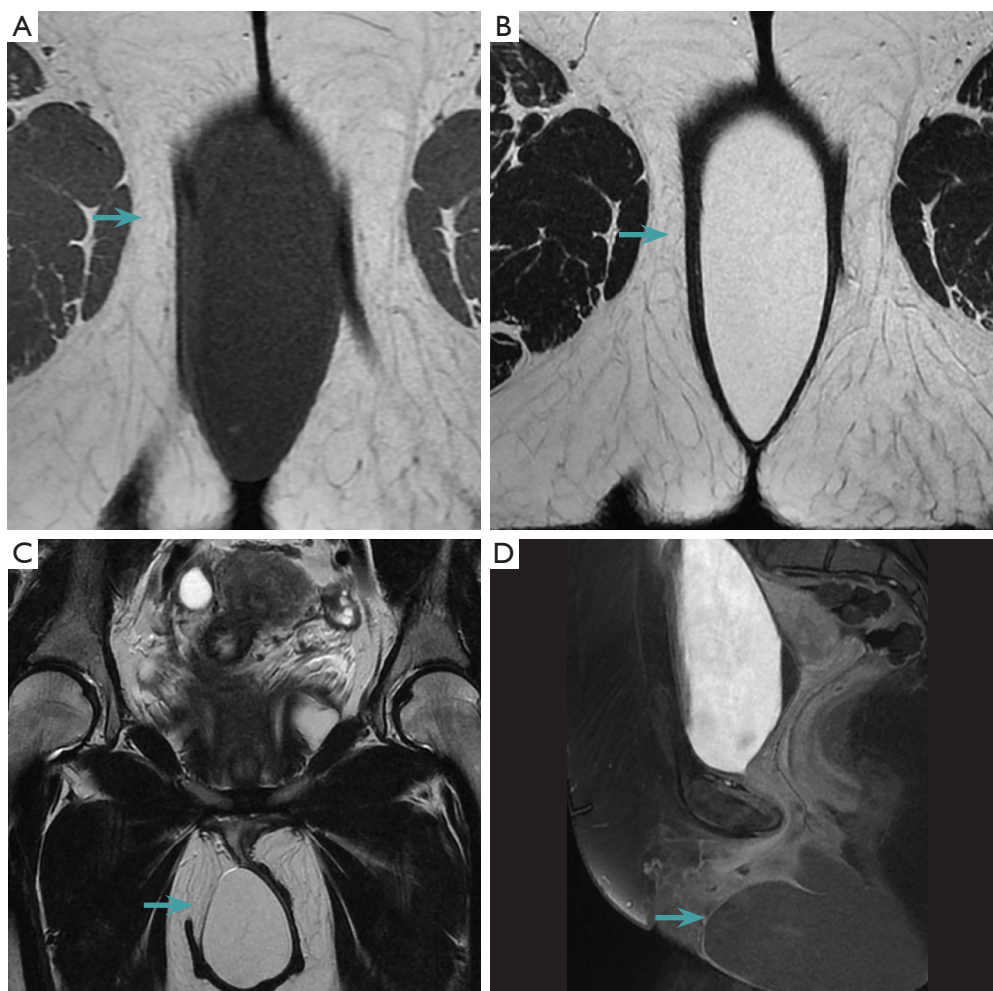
Epidermal inclusion cyst. VSD-enhanced pelvic MRI shows a large vulvar cyst (green arrows) below the perineal membrane, hypointense on T1 (A,D), hyperintense on T2 (B,C), with no significant enhancement on VSD (D). MRI, magnetic resonance imaging; VSD, vaginal saline distension.
